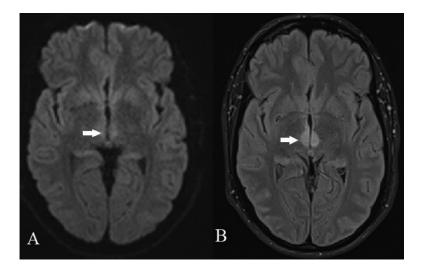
Cranial MRI on axial DWI (A) and FLAIR (B) sequences demonstrated high signal intensity on bilateral paramedian thalami (arrows).
